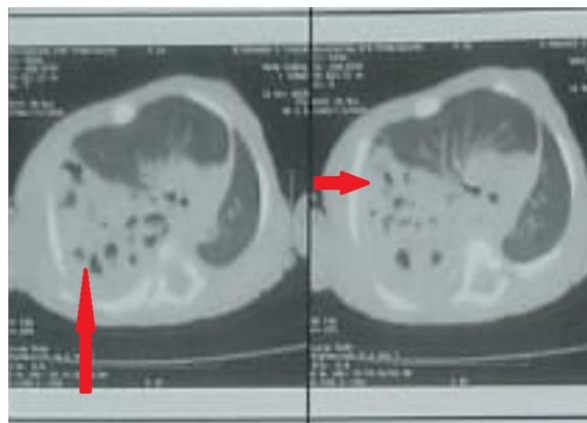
a thoracic CT was performed objectifying a right diaphragmatic hernia
